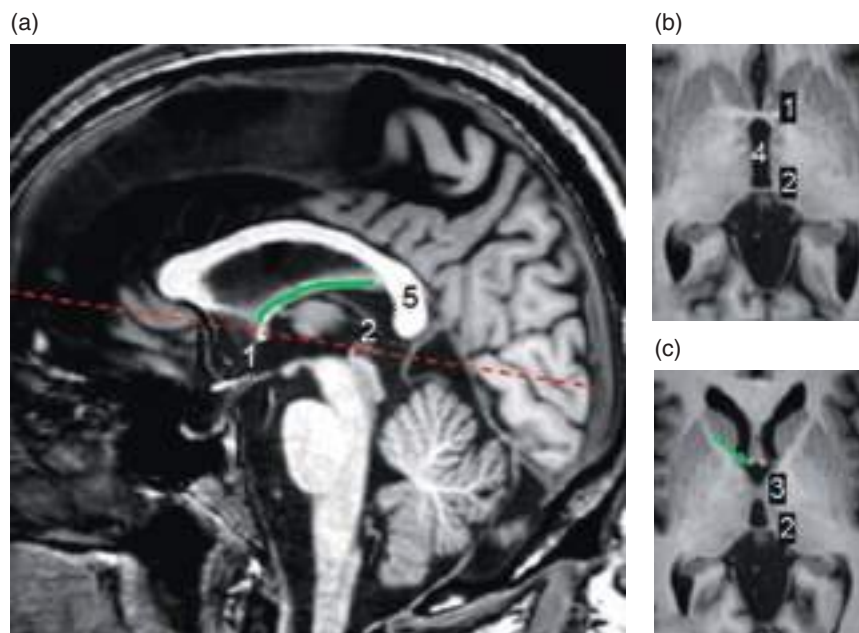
Cerebral commissures. (a) Sagittal T1-weighted MRI. (b, c) Axial T1-weighted MRI in two different patients. The intercommissural line, which is used as a landmark to acquire sequences in the axial plane, can be seen in (a) (dashed red line). (b) The anterior and posterior commissures. (c) The interthalamic adhesion, a variant of normality. 1, anterior commissure; 2, posterior commissure; 3, interthalamic adhesion; 4, third ventricle; 5, corpus callosum. Green line (a) and arrow (c) show the fornix.
